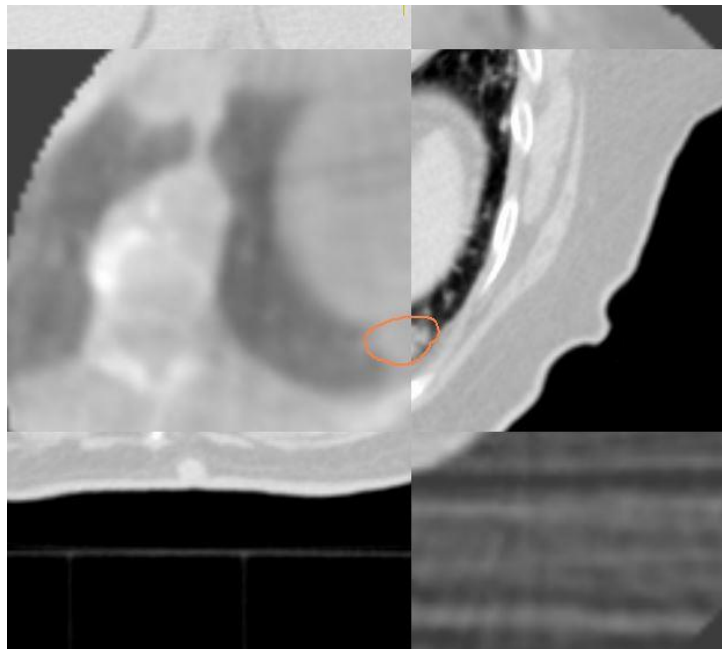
Matching 4DCT and 4DCBCT images for a single fraction with a diaphragm lesion in a patient
